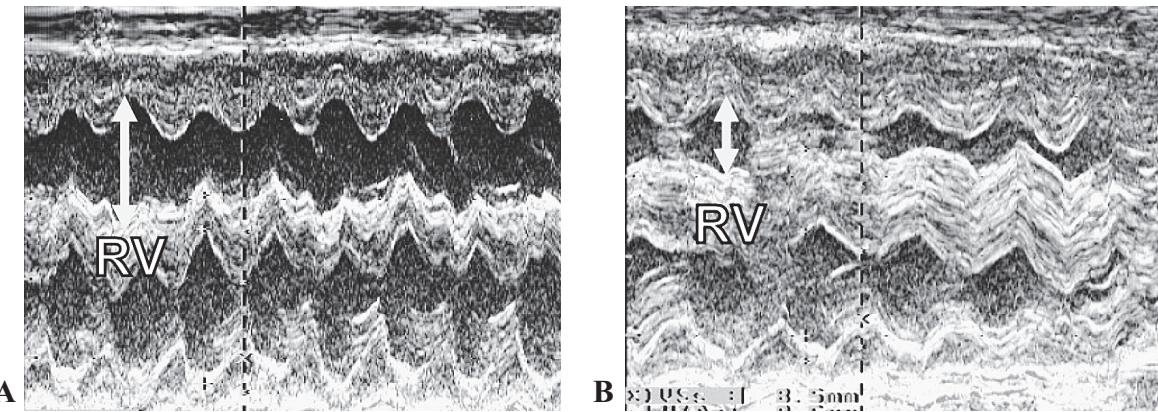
M-Mode echocardiogram revealed right ventricular (RV) dilatation on 3A which resolved 6 hours later (3B)
